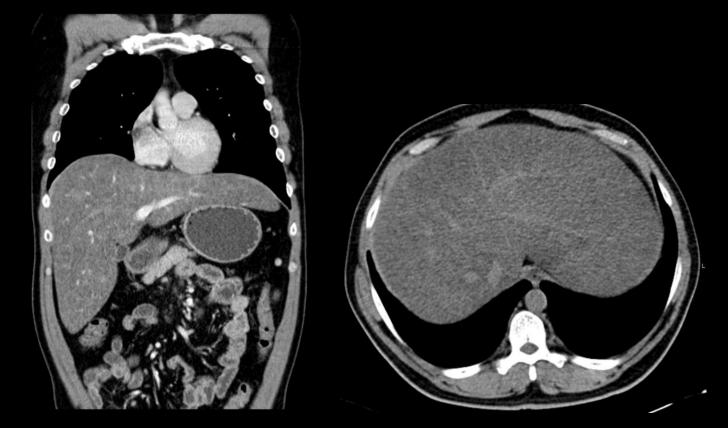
Coronal and axial CT scans demonstrating hepatomegaly and difuse steatosis (low HU values, low density).
